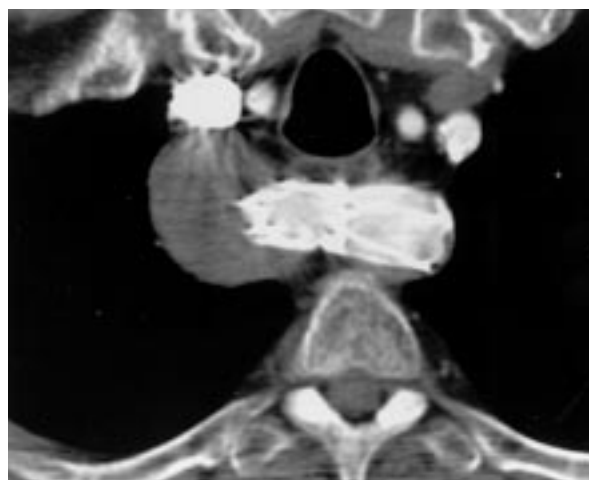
Repeated computed tomography scan 1 year after stent graft placement shows persistent thrombosis of the aneurysm. Maximal diameter of the aneurysm is 3.8 cm.
